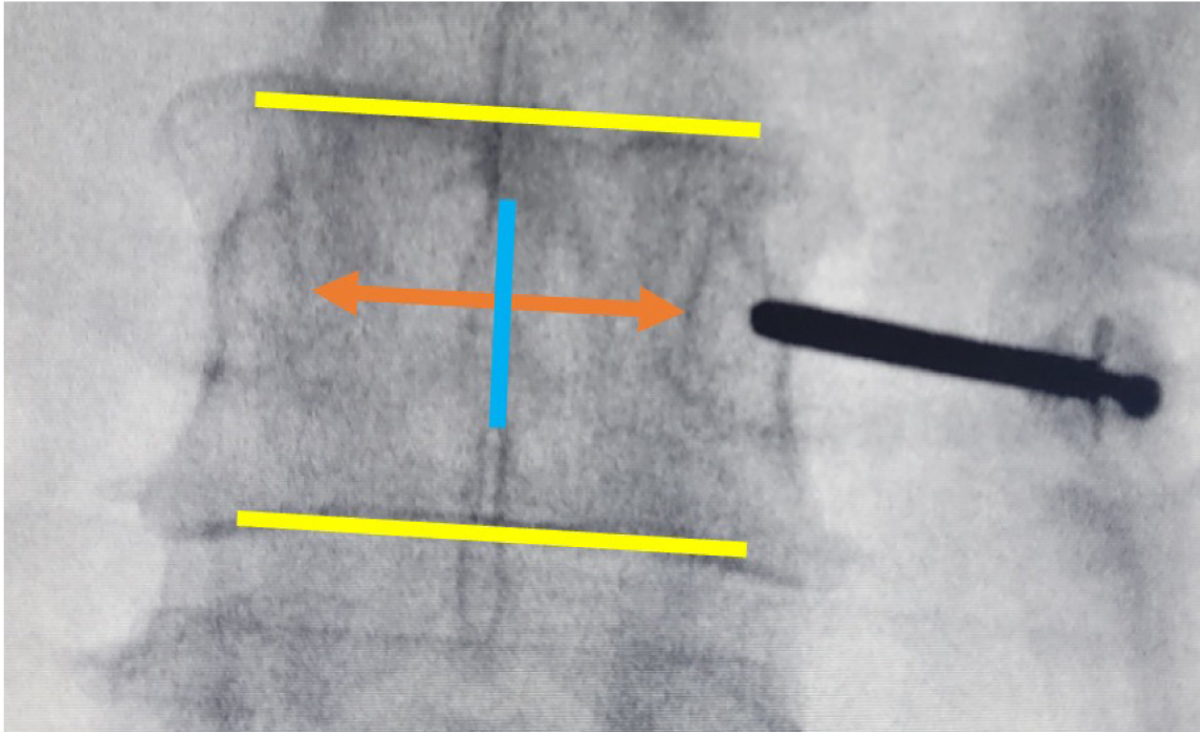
True AP X-ray consists of “squaring” of the endplates (yellow lines), equi-distance of well-defined oval pedicles from the spinous process (blue line). The Jamshidi needle tip is docked at the 3 O’clock position of the pedicle.
